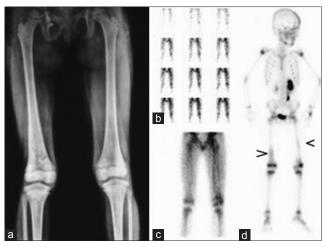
A 4-year-old male child presented with weakness of few days in lower extremities and inability to bear weight. There was mild fever. Plain radiograph was unremarkable; (a) A working diagnosis of osteomyelitis of femur was made clinically. Three phase bone scan revealed diffuse increased tracer localization in the distal shaft of right femur (>) and mid shaft of left femur (<); (d) Perfusion and blood pool images did not favor the diagnosis of osteomyelitis; (b,c) Hematologic work up was suggested suspecting this to be bone cortical infarcts. Subsequent work up revealed acute myeloid leukemia
